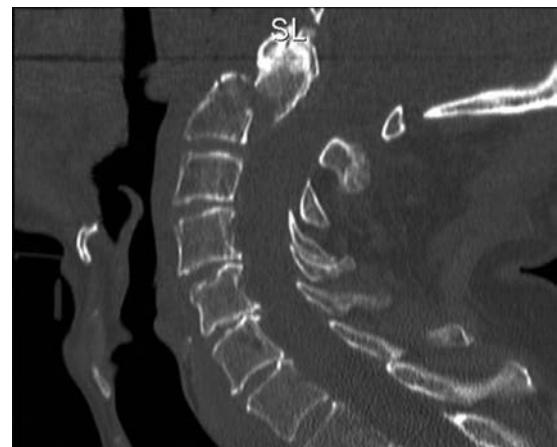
Sagittal CT of initial injury, showing displacement of 10mm, and angulation of 19 degrees.
